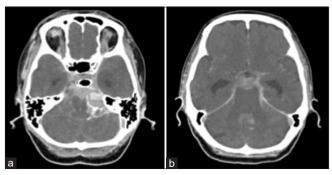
(a and b) Noncontrast computed tomography performed just after the initial digital subtraction angiography showing contrast extravasation with increasing amount of subarachnoid hemorrhage predominantly in the left cerebellopontine cistern.
